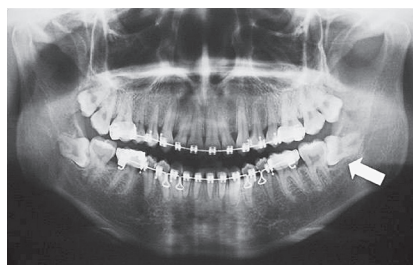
Panoramic radiograph showing orthodontic indication for extraction of tooth #38.
